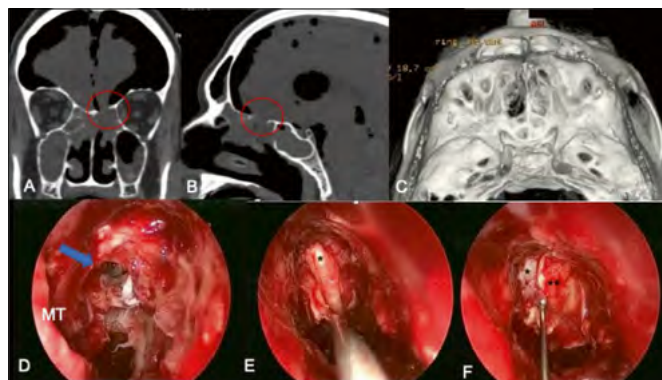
A CT scan in coronal (A) sagittal (B) and 3D reconstruction (C) of posttraumatic (iatrogenic) CSF leak at the level of the left ethmoid sinus occurred during Functional Endoscopic Sinus Surgery (FESS) surgery for nasal polyposis. A massive pneumocephalus occurred due to delayed diagnosis of intraoperative leak. The patient underwent to endoscopic repair of the wide defect (D arrow) using fascia lata graft in a multilayer fashion (E and F): first* underlay layer and second overlay layer + rotation of middle turbinate (MT).
